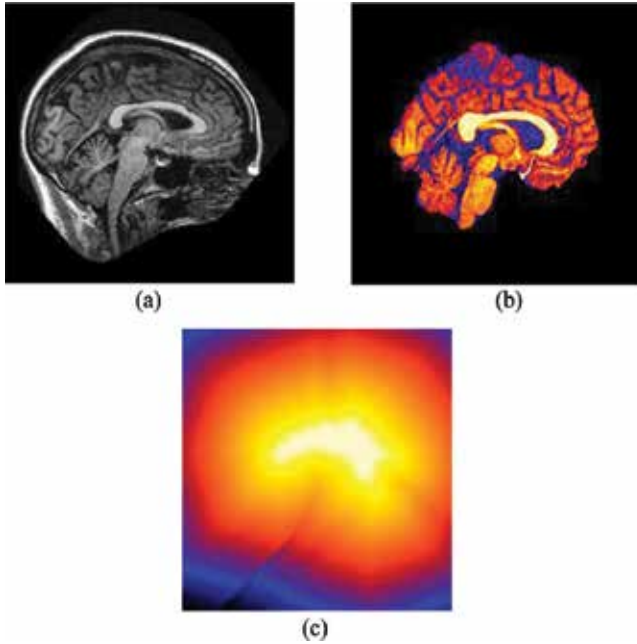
Preprocessing steps of brain MR image for feature extraction. (a) Raw MR image, (b) Segmented image, and (c) Signed distance.
